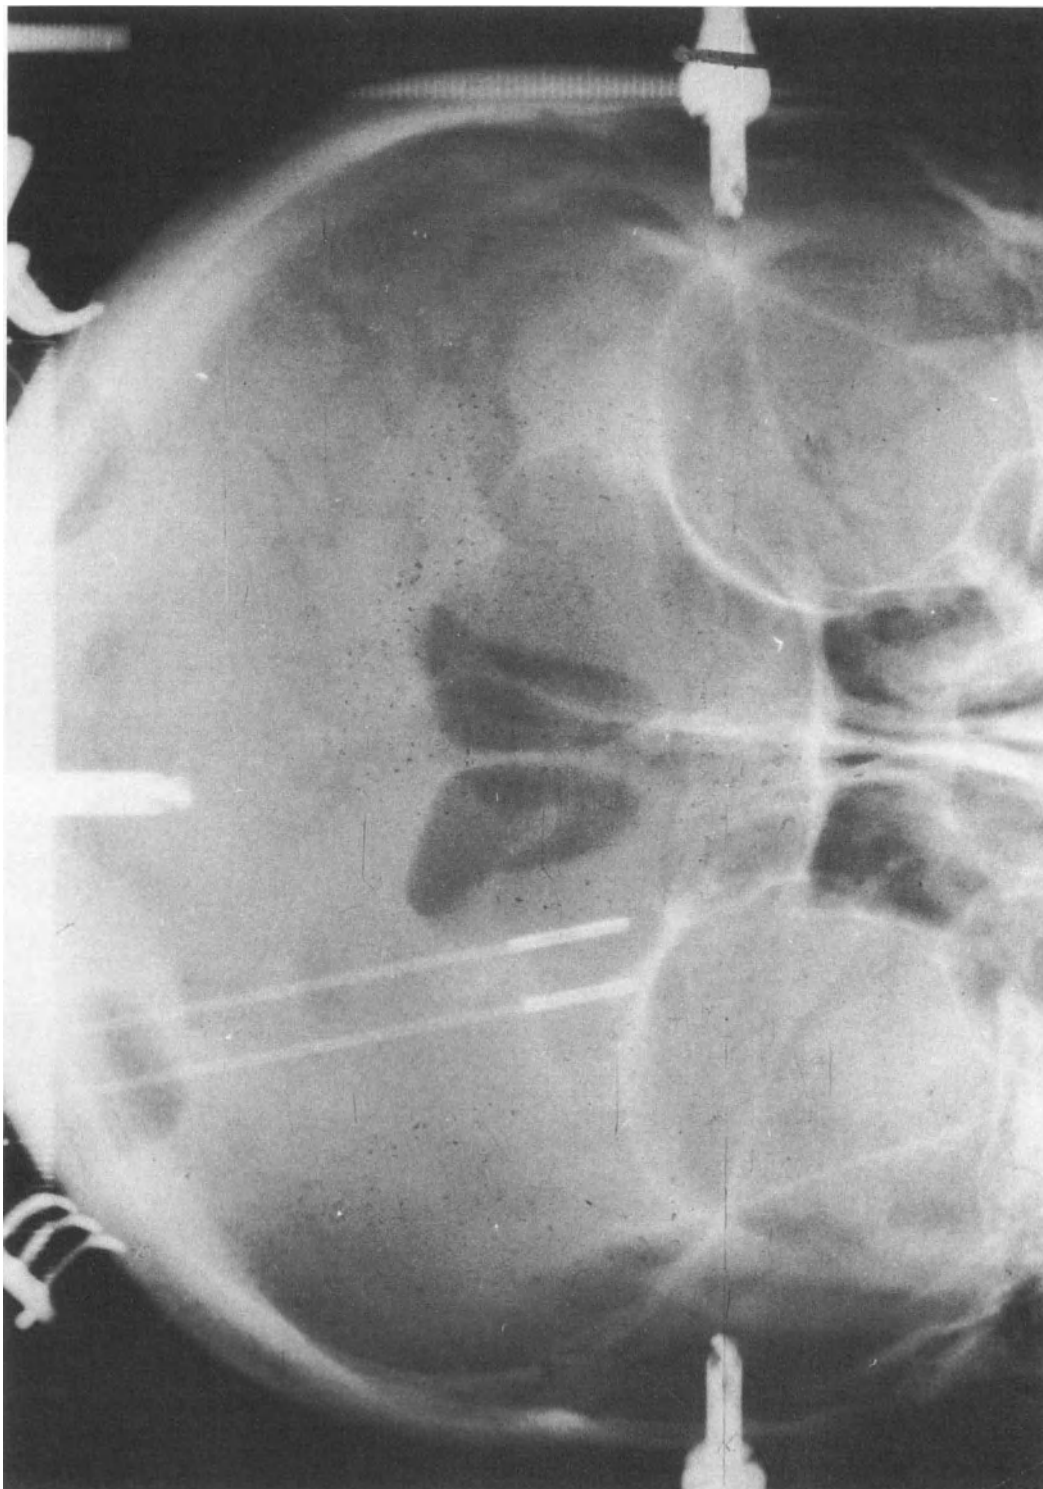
Intraoperative, stereotactic radiograph showing bipolar electrodes for lesion production in the internal capsule.
